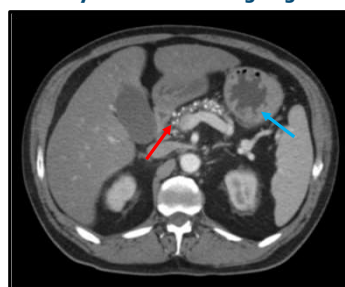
CT A/P notable for acute diverticulitis of descending colon w/ abscess (blue arrow), liver parenchymal dz, chronic pancreatitis (red arrow), incidental lytic lesions
